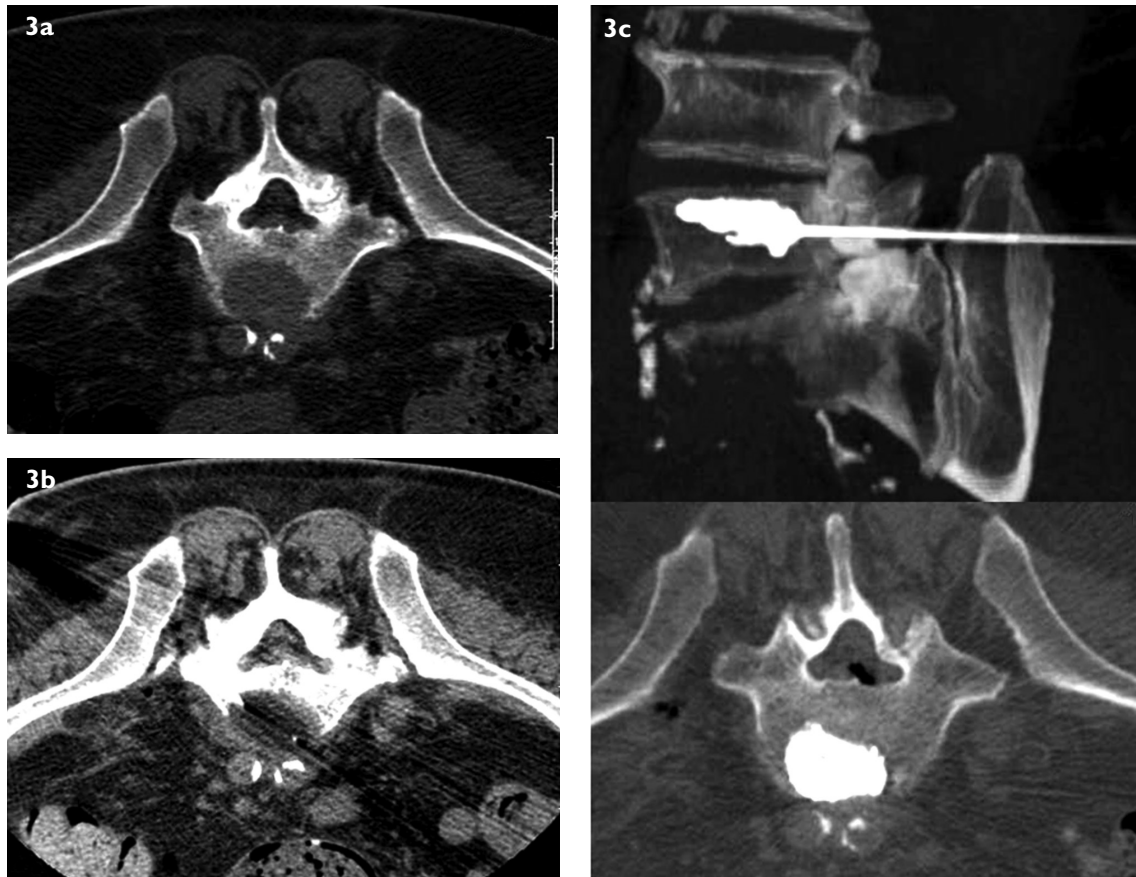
Axial CT image (a) at the level of the sacrum shows the tip of the radiofrequency electrode positioned at the centre of the osteolytic lesion; (b) at the same level after the injection of polymethylmethacrylate shows no complications.
